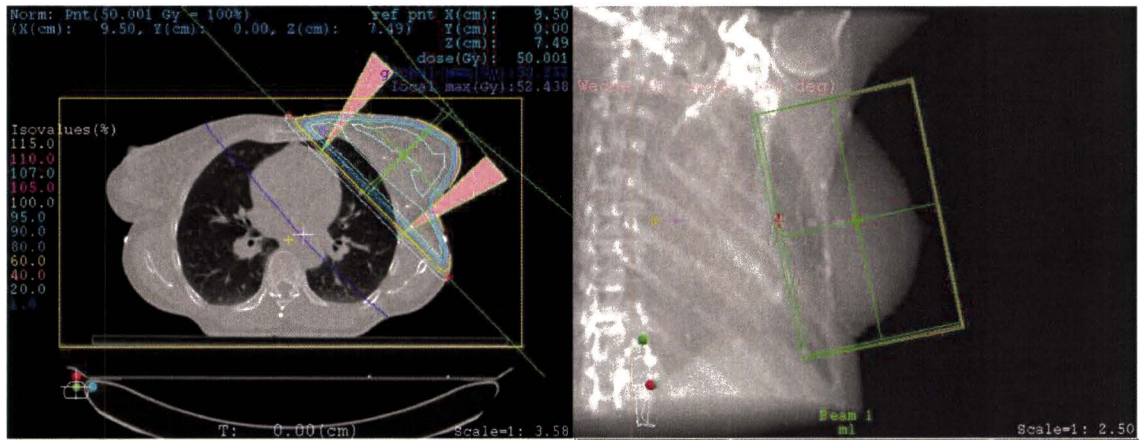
The treatment planning system (XiO, CMS, St. Louis (MO), USA) calculates the dose distribution in the patient. Isodose lines are plotted on top of the CT-scan of the patient (right plot). The plot on the left shows the field size superimposed on the digitally reconstructed radiograph (DRR).
